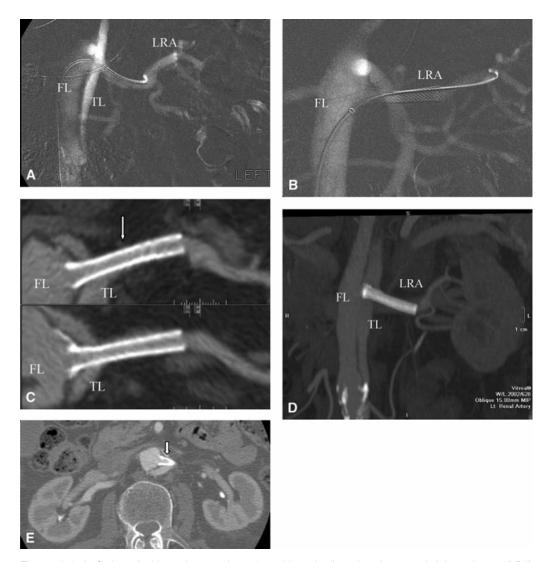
A, Carbon dioxide angiogram of a patient with aortic dissection shows static left renal artery (LRA) obstruction and the true lumen (TL), false lumen (FL), and the dissection flap prolapsing into the LRA. Note that the catheter is in the FL. B, Carbon dioxide angiogram of the LRA after fenestration and LRA stenting. C and D, Three-dimensional reformats of the LRA stent (arrow). The true and false aortic lumina are identified. Note the stent extending through the aortic TL. E, Cross-sectional computed tomography image of the same patient at the 4-month follow-up. The arrow is directed at the previously placed LRA stent; note the bright and symmetric left renal contrast enhancement supporting adequate perfusion. (From Barnes DM, Williams D, Dasika N, et al. A single-center experience treating renal malperfusion after aortic dissection with central aortic fenestration and renal artery stenting. J Vasc Surg 2008;47:903–10.)
